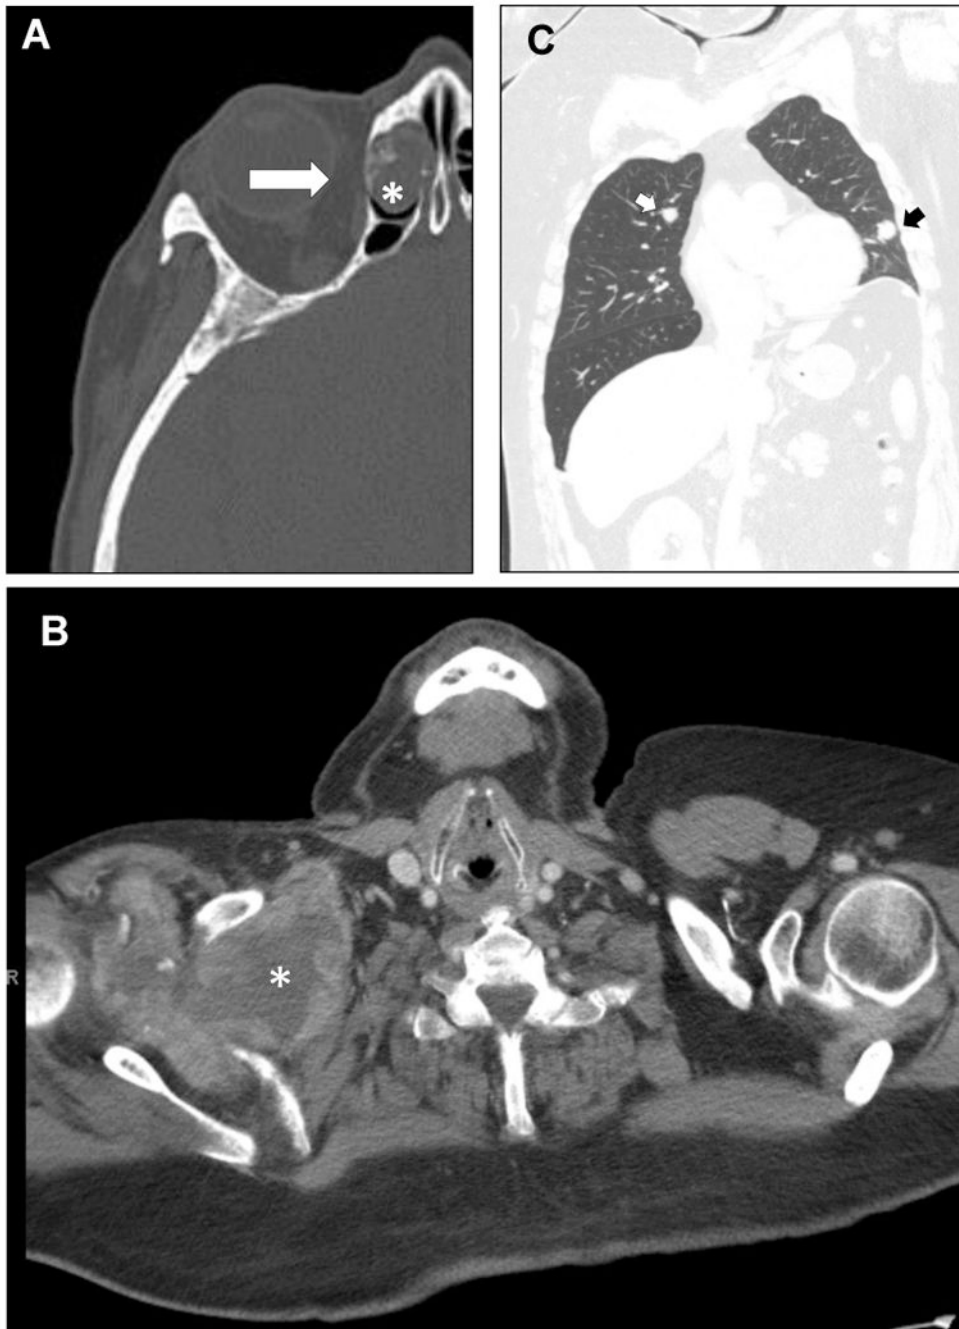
Imaging findings for head and neck SFTs. A. The sinonasal tract was the most prevalent site of involvement, this CT scan showing a tumor based in the nasal cavity invading the ethmoidal cells (lesion, *) with erosion into the orbit (arrow). B. A single SFT with sarcomatous dedifferentiation arose in the base of the neck (*) and extending caudad through the level of the thyroid cartilage. C. Pulmonary metastases (arrows) were observed.
